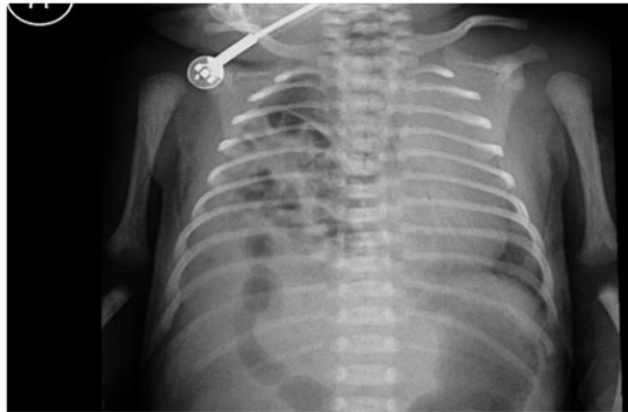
Antero-Posterior Chest X-ray After Birth
